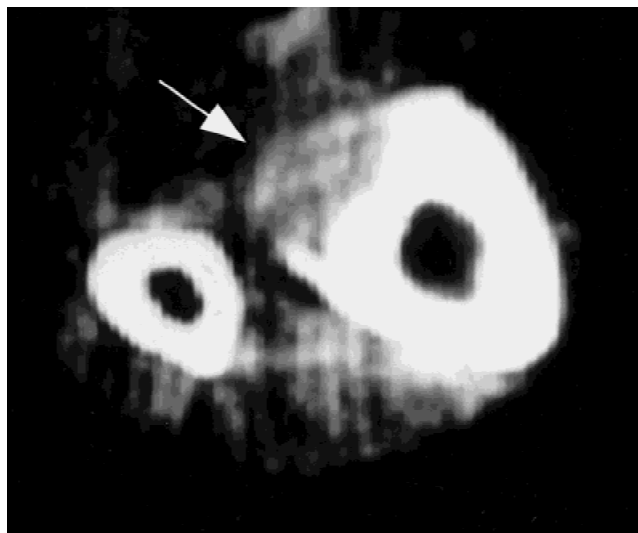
CT section of lesion in Figure 3 demonstrates cortical destruction with ring of periosteal bone formation (arrow).
